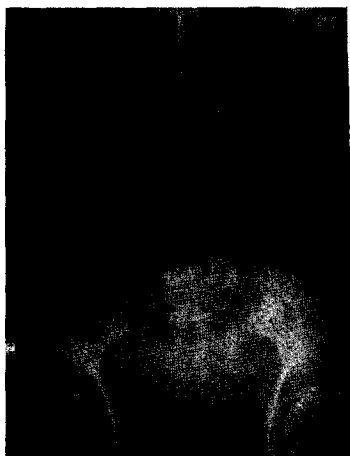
"Scout film" of abdomen in case of small intestinal obstruction. This shows the parallel arrangement and transverse position of the intestinal coils and their central location in the roentgenogram. The fine cross-striations are characteristic of dilated small intestine.
